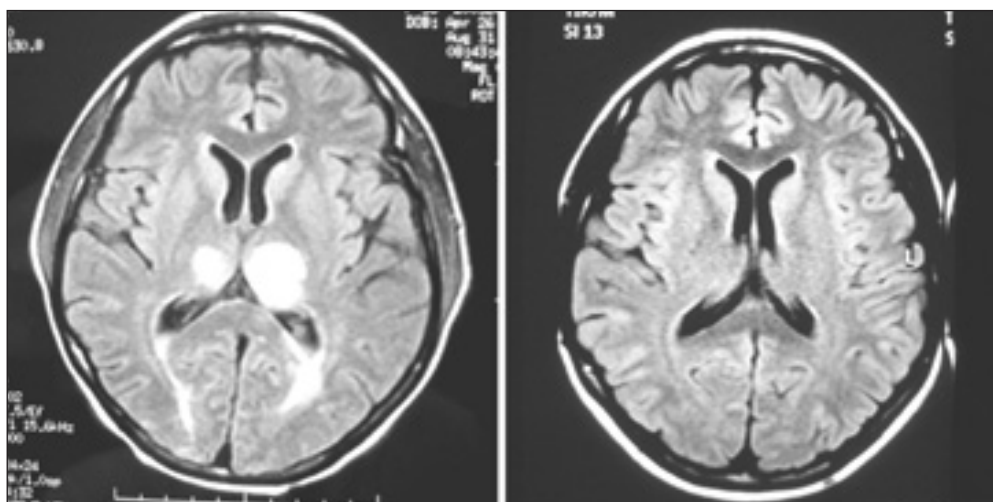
Case report of a 31-year-old patient with an ongoing acute confusional state occurred after a recent HELLP syndrome. The figures show the dramatic improvement of some supratentorial large hyperintense lesions on MRI-FLAIR sequences before (left) and after (right) treatment with i.v. CYC (1000 mg), and 3 CS pulses (1 g) combined with PEX.
